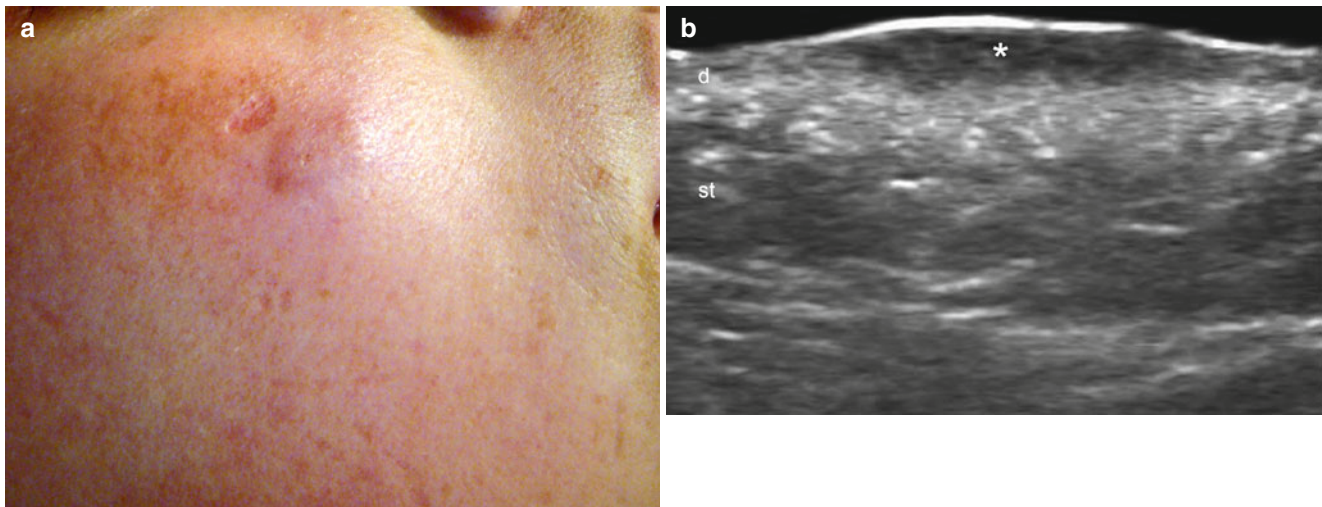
(a–e) Cutaneous lupus (active phase) (a) Clinical image shows erythematous swelling in the right cheek. (b) Gray scale ultrasound image (transverse view) demonstrates fusiform-shaped thickening and decreased echogenicity of the upper dermis (*). There is also increased echogenicity of the lower dermis and upper subcutaneous tissue. (c) Color Doppler ultrasound image (transverse view) shows
